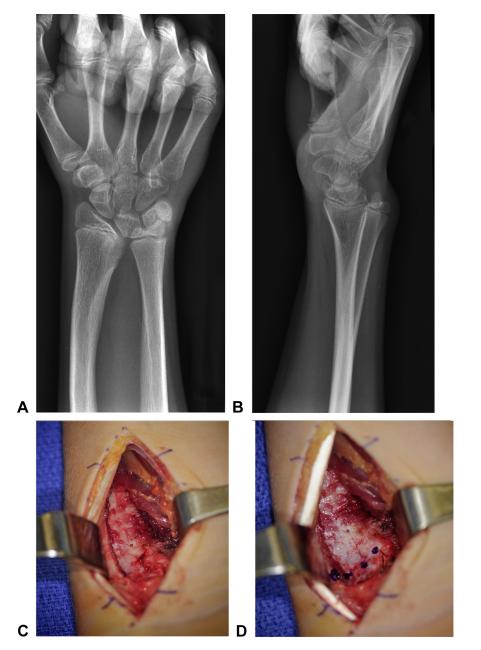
An 11-year-old with Madelung deformity. (Courtesy of Shriners Hospitals for Children, Philadelphia, PA.) A Anteroposterior x-ray. B Lateral x-ray. C Exposure of volar radius. D Markings with dome configuration. (Continued.)
